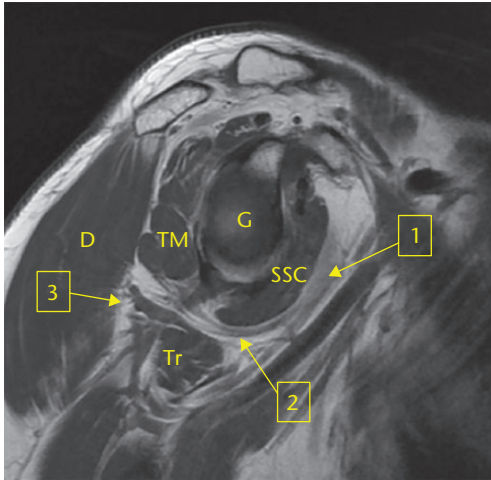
Sagittal MR image of the shoulder, showing the anatomical relationships of the axillary nerve. The axillary nerve passes down the anterior part of the subscapularis muscle (SSC, arrow 1) and past the inferior pole of the glenoid (G, arrow 2) before reaching the deep face of the deltoid muscle (D, arrow 3). TM: teres minor; Tr: Triceps.
